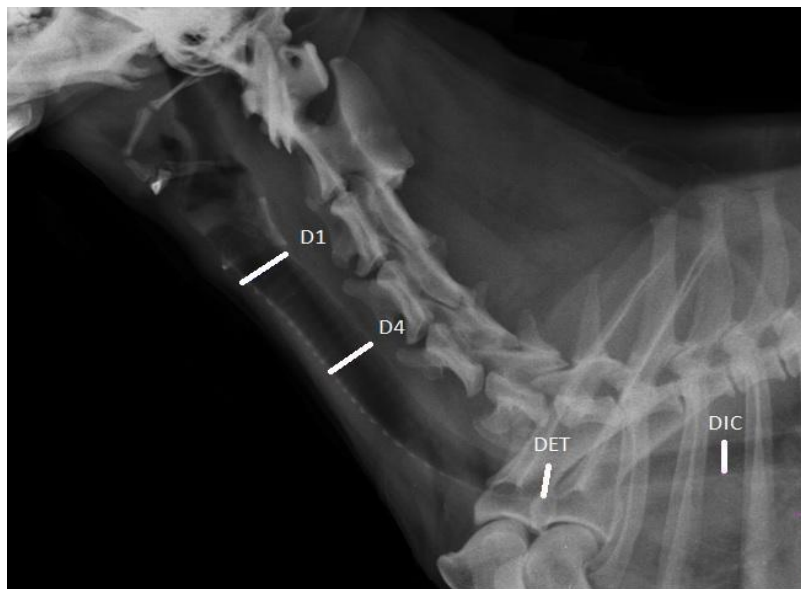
Radiographic image of the cervicothoracic region via a lateral right-facing screening that reveals the localized readings for all variables involved in the measurement of the trachea's internal diameter. D1 (tracheal internal diameter at the first tracheal ring zone); D4 (tracheal internal diameter at the region between the fourth and fifth cervical vertebrae); DET (tracheal internal diameter at the thoracic inlet); and, DIC (tracheal internal diameter at the second intercostal space region).
